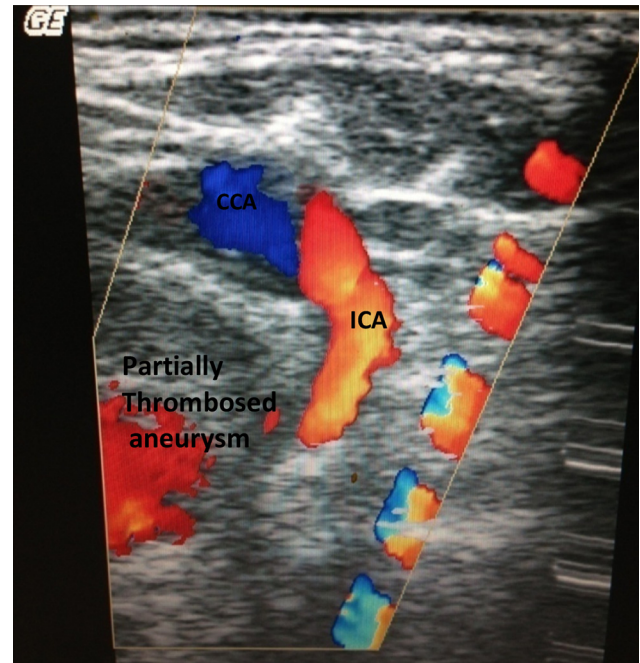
Duplex ultrasound image of the partially thrombosed aneurysm from left ICA.
